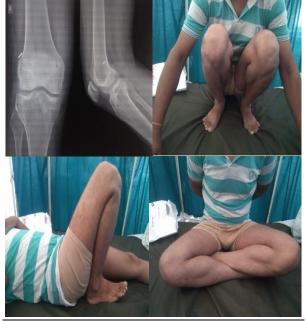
Post-op x-ray and functional outcome 38 y/o Male, Right ACL tear, 18 months follow up, Lysholm score 94/100.
